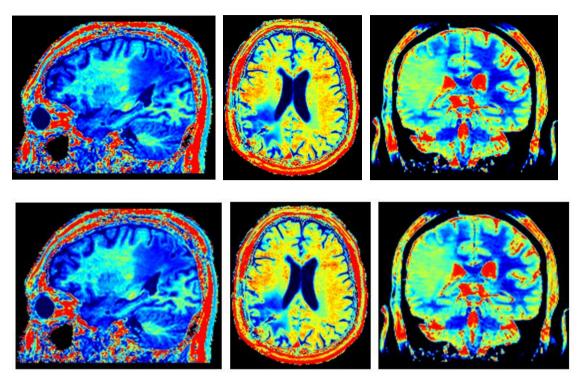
SyntheticMR has developed an MRI sequence that in 6 minutes can provide a 1 mm isotropic volume of R1 relaxation rate (left), R2 relaxation rate (middle) and proton density (right). This is about 10 times faster compared to state of the art before IMPACT. R1 relaxation rate = 1/T1 relaxation time, R2 relaxation rate = 1/T2 relaxation time. These quantitative measurements can be used to, for example, better define the tumor border
